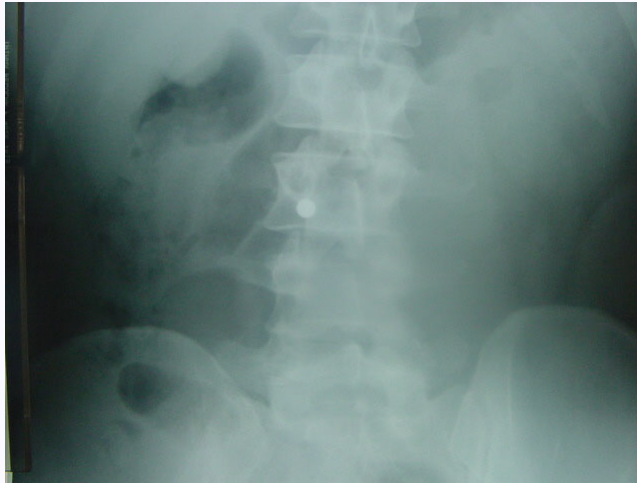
Plain abdominal X-ray demonstrating bullet at L3 level.
